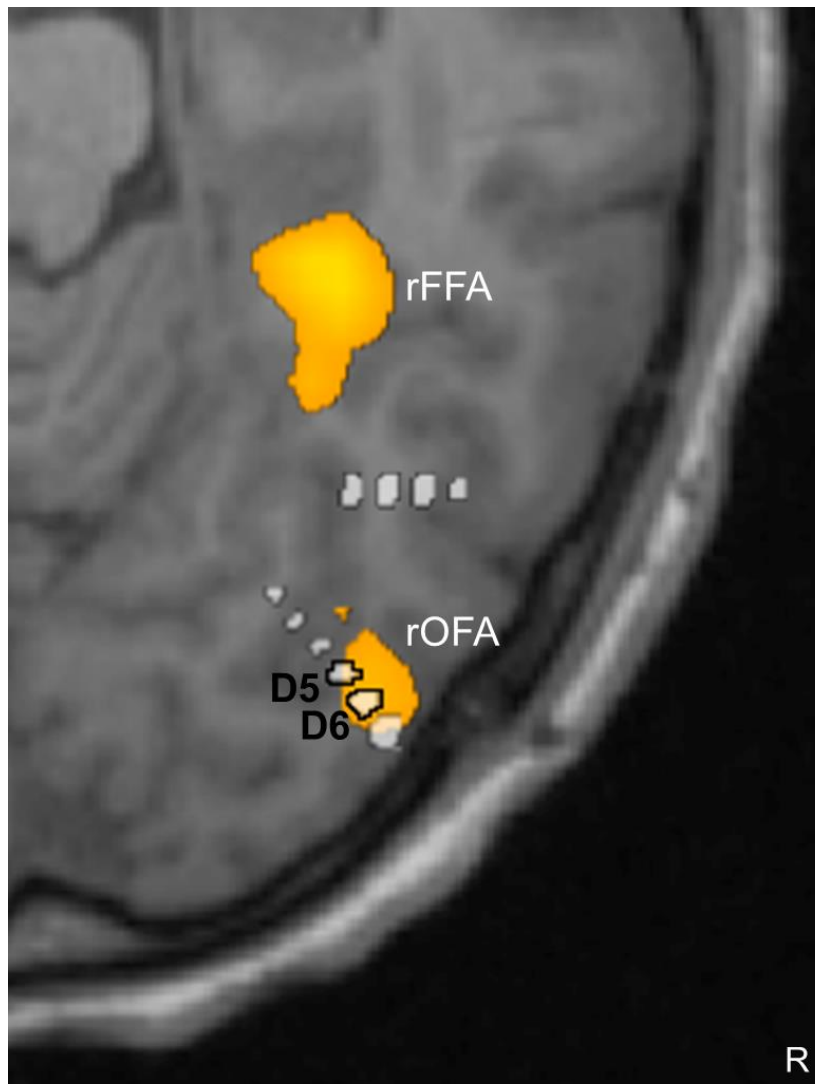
Functional location of the 2 stimulated contacts D5-D6 inducing reproducible impairment of individual face discrimination (6 times). Contacts D5-D6 are both located within the right OFA. D7 is located also within this region also, just laterally to D6. The figure was obtained by fusing the functional MRI and the post-operative stereotactic CT-scan.
